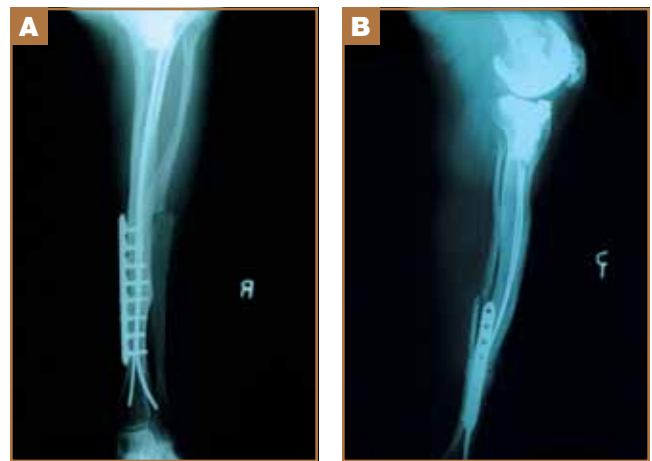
AP (A) and lateral (B) radiographs of right tibia after plating with healed osteotomy.
